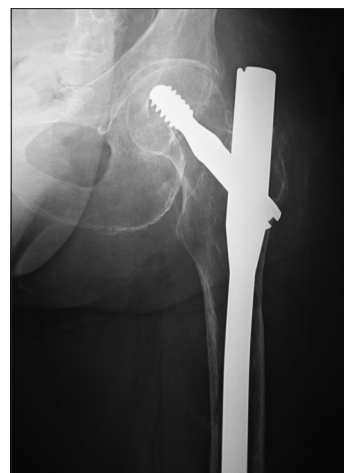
Preoperative X-ray documenting the protruding apex of the intramedullary nail
